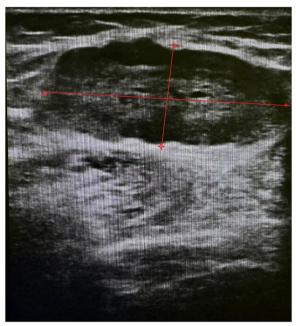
Ultrasound examination of the left breast showing a heterogeneously hypoechoic oval nodule with lobulated margins and well-defined borders, located in the upper outer quadrant
